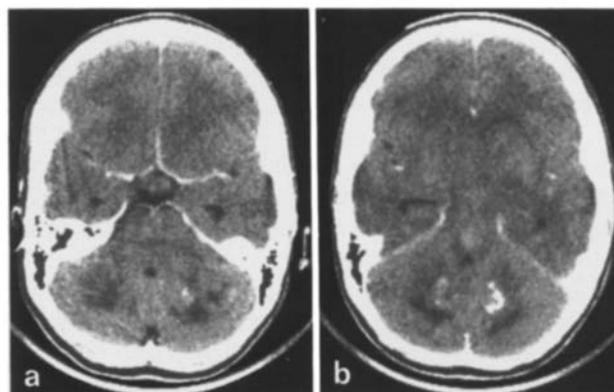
a and b. Case 1. a Scan through optic chiasm and mid-pons. b Scan through level of basal ganglia and pontomesencephalic junction. Contrast-enhanced CT reveals diffuse mass effect involving midline structures, with enlargement of the pons and optic chiasm, and compression of the ventricles. Enhancement is seen solely in the superior aspect of the pons. The cerebellum demonstrates bilateral low densities associated with calcifications, presumably dystrophic.
